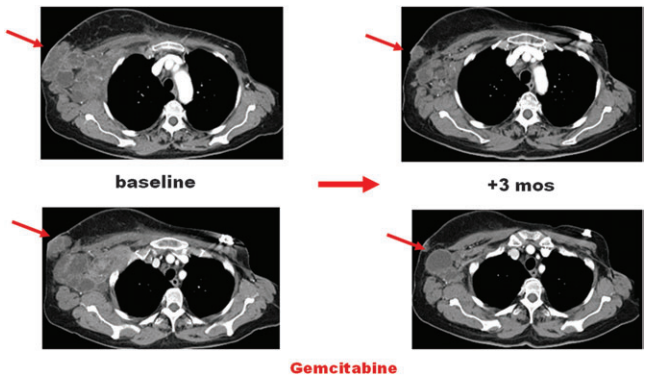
Post-radiation therapy breast angiosarcoma treated with gemcitabine: computed tomography scan (arterial phase after contrast medium). A RECIST partial response after 3 months of treatment with gemcitabine was obtained and patient underwent complete surgical resection.
